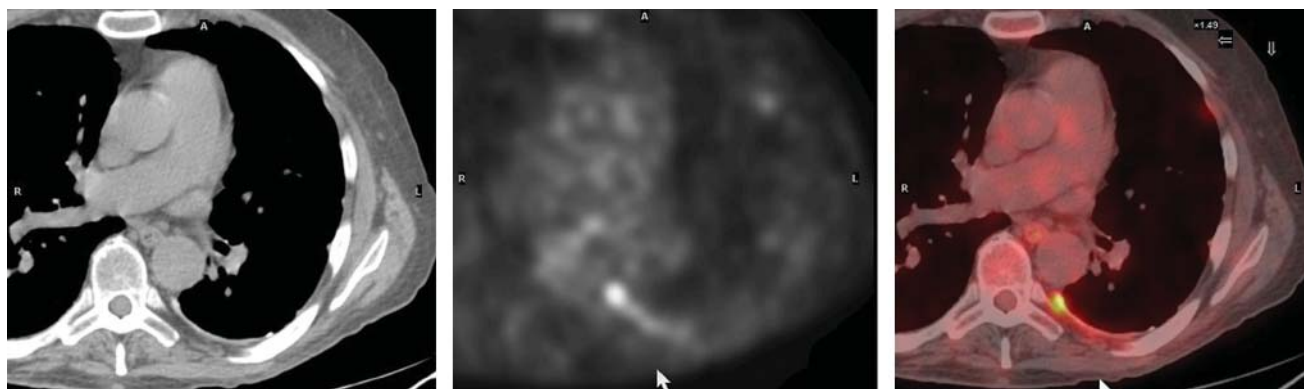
Pleurodesis. CT demonstrates left posterior pleural thickening. Hypermetabolism is associated with this area of pleural thickening. Additional sites of pleural hypermetabolism were seen throughout left pleural space on whole-body images. Patient had had pleurodesis in past, consistent with current findings.
